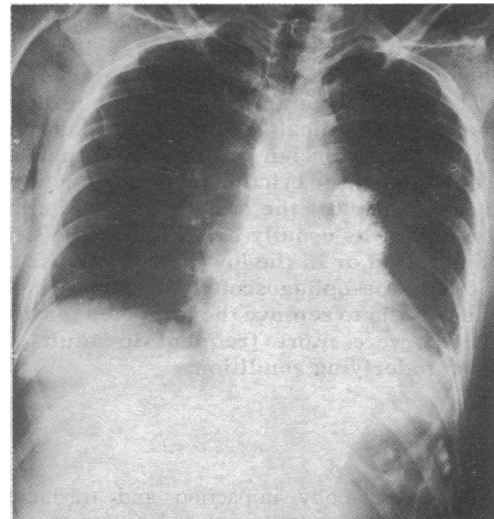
Chest x-ray picture of 45-year-old woman. Ingestion of lipiodol after oesophagoscopy showed leakage of lipiodol from the lower end of the oesophagus into the left pleural space.
